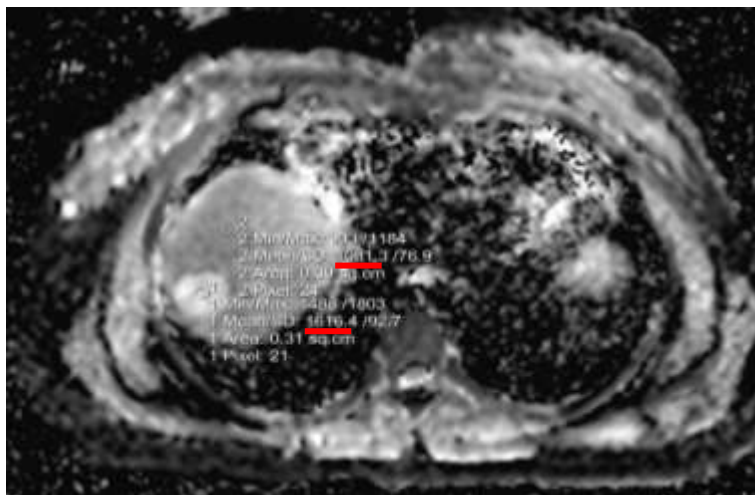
43 female patient with HFL is seen at abdominal U/S. Dynamic MRI was done this figure showing ADC map of liver showing HFL and ROIs were applied on both HFL (ROI 2 reading 1616) and on liver parenchyma (ROI 1 reading 1081). ADC ratio = 1.49
